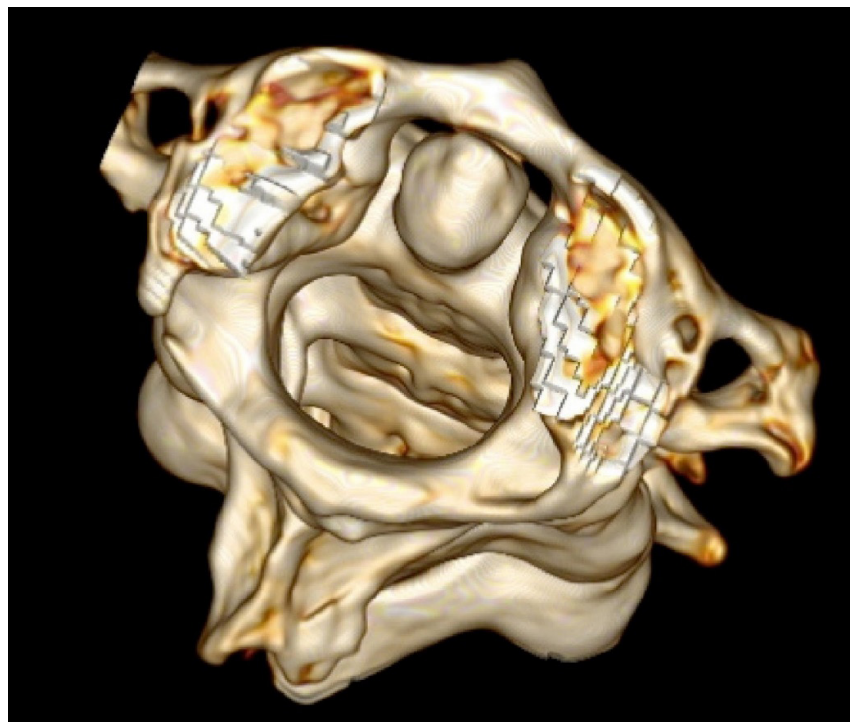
3D image of the atlantodental distance in a thin-section CT
